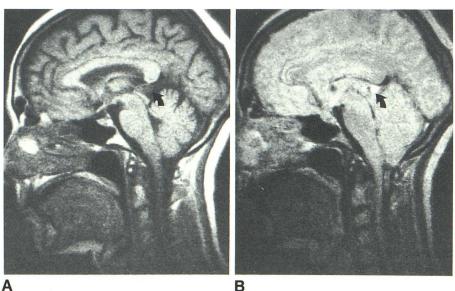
Sagittal T1- (A) and T2- (B) weighted MR images at 0.5 T show typical appearance of pineal cyst (arrows).
